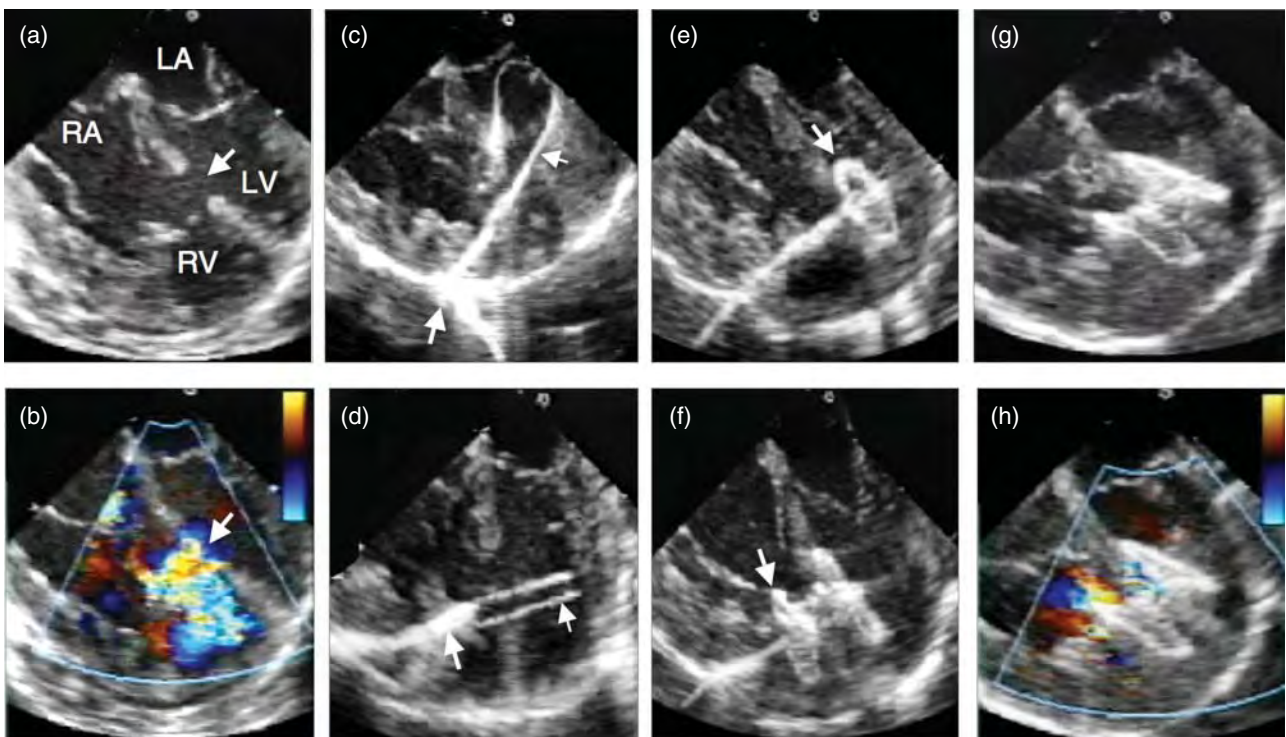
(a) Transesophageal echocardiogram four-chamber view showing a large mid-muscular VSD (white arrow). (b) Color flow across the VSD showing left to right shunt. (c) Transventricular wire crossing the anterior wall of the RV into LV through the VSD. (d) Delivery sheath crossing the anterior wall of the RV into LV through the VSD. (e) Delivery of LV disc. (f) Delivery of RV disc. (g) Release of the device into the VSD. (h) Color flow showing no residual shunt.
